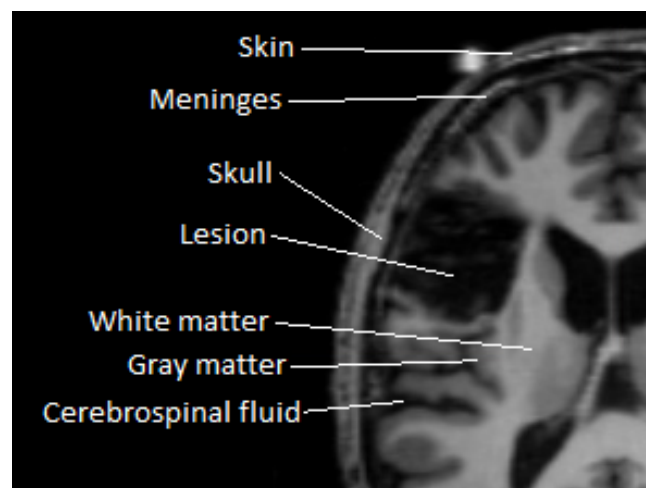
Parts of a brain in a T1-weighted MRI scan. Lesions are low intensity areas similar to CSF.
